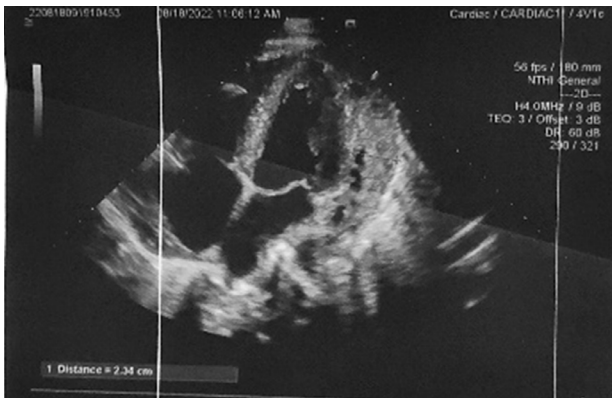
Echocardiograph with pericardial effusion
